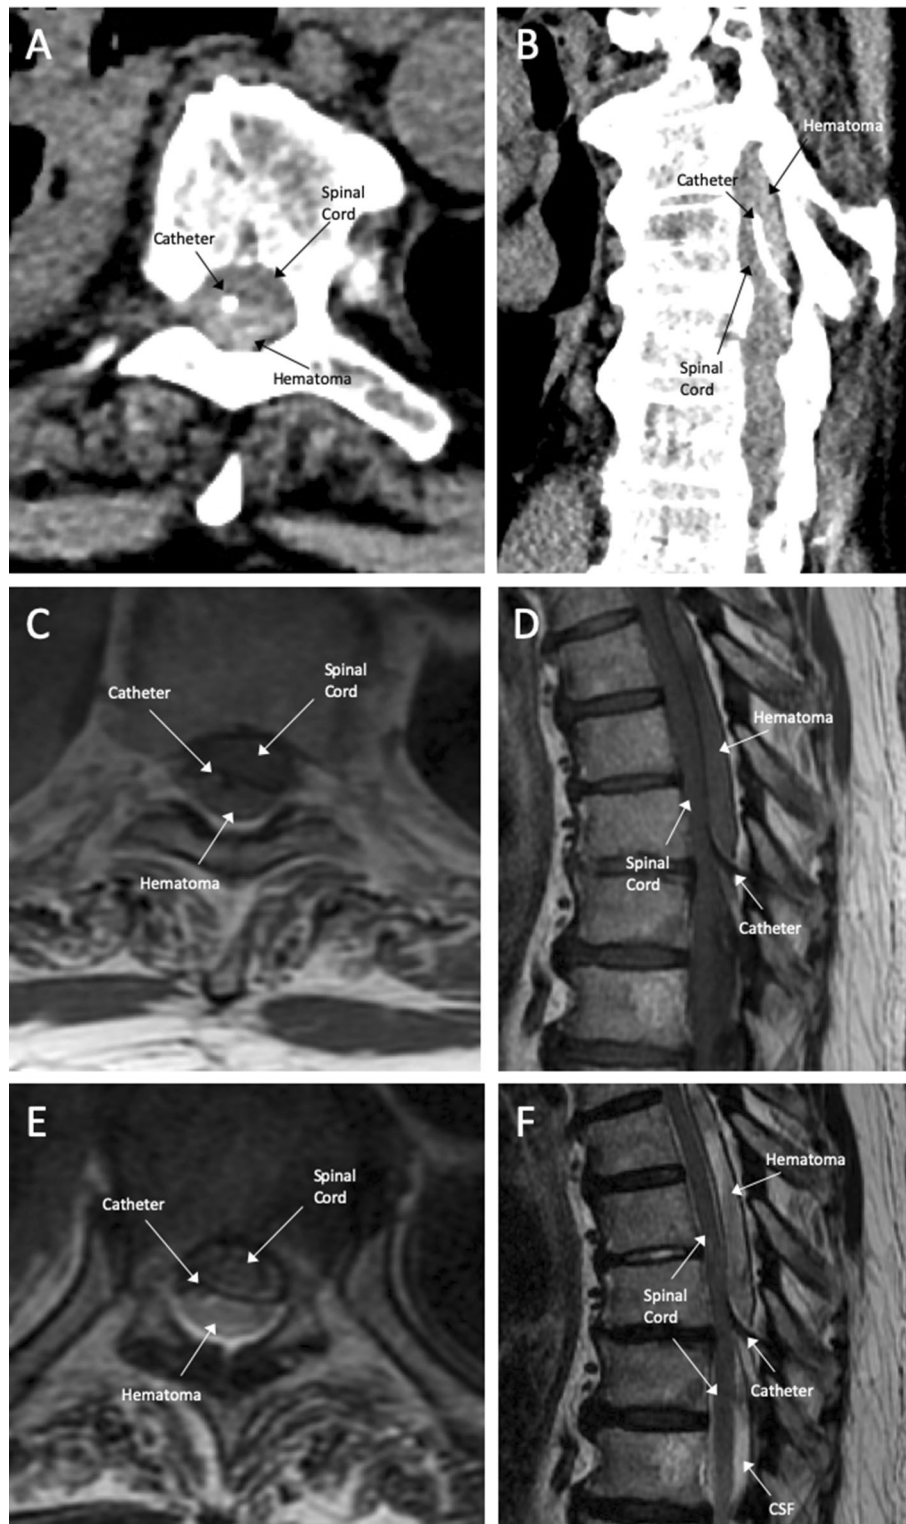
Figure Epidural hematoma in the same patient visualized by computed tomography *versus* magnetic resonance imaging. (A) axial and (B) sagittal computed tomography planes show the epidural hematoma as a slightly more radiopaque structure within the spinal canal compared to the spinal cord. Comparing the epidural hematoma visualization using magnetic resonance T1-weighted (C) axial and (D) sagittal images to T2-weighted (E) axial and (F) sagittal images, the T2-weighted images show greater discrimination between the hematoma and spinal cord. The epidural hematoma, spinal cord, and epidural catheter are labeled in all images. Cerebrospinal fluid (CSF) is labeled in the T2-weighted sagittal image.
